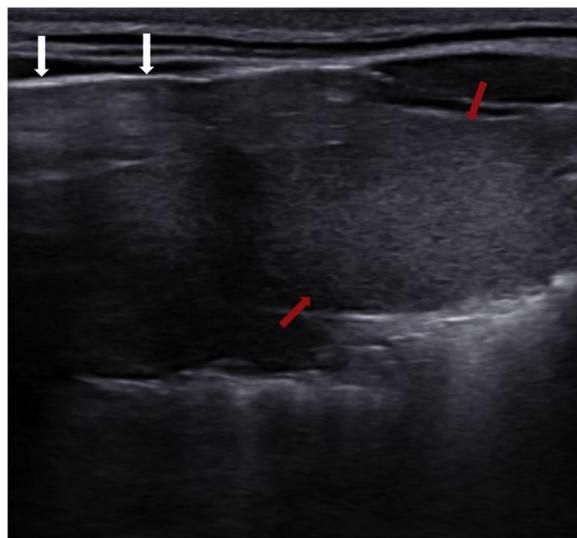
After 24 h from hospital admission, the ultrasound cervical sagittal scan shows the reduction of the acoustic barrier (white arrows) due to the air absorption, with major visualization of the right thyroid lobe (red arrows).
